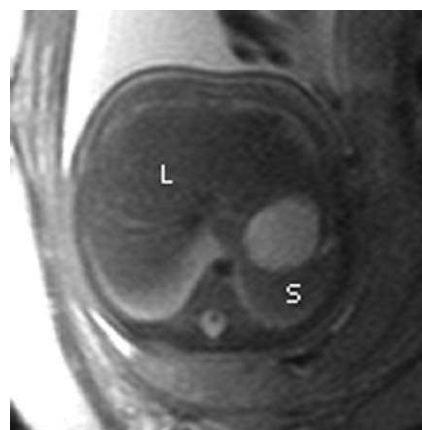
Fetus at 32 weeks' gestation. Note the spleen (s), which is rarely seen in fetal US but routinely visualized on fetal MR imaging. The liver (l) also is labeled.
